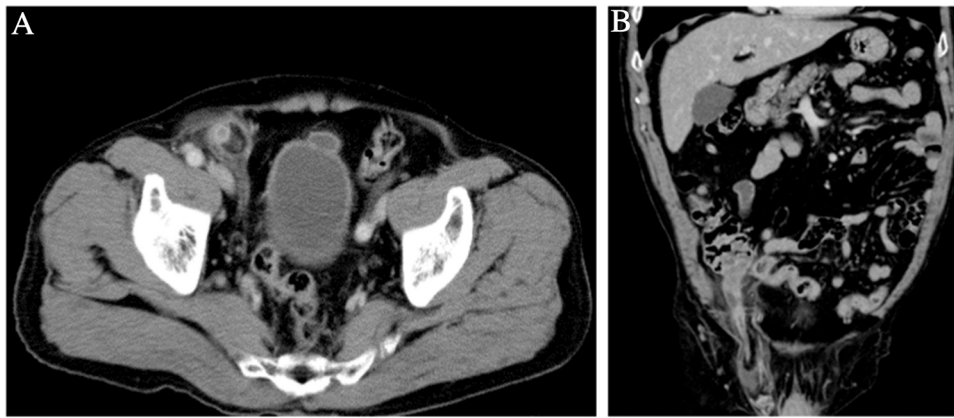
Abdominal contrast-enhanced computed tomography images. Inflamed appendix incarcerated into the right inguinal canal.
